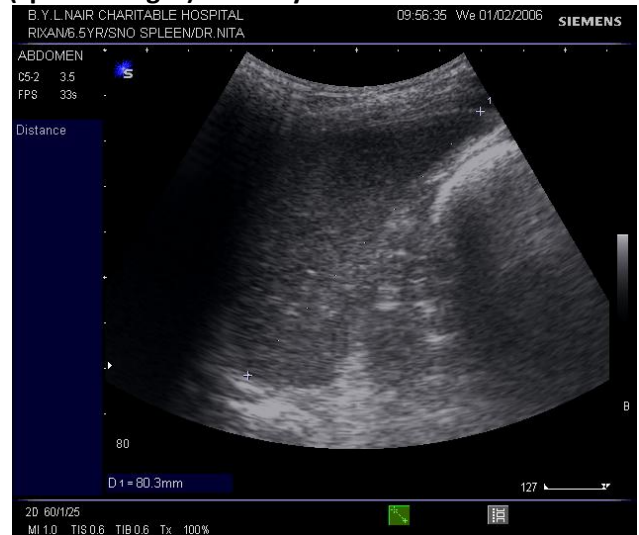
Gray scale, B mode sonogram of the spleen in a patient of thalassemia major showing splenomegaly.
